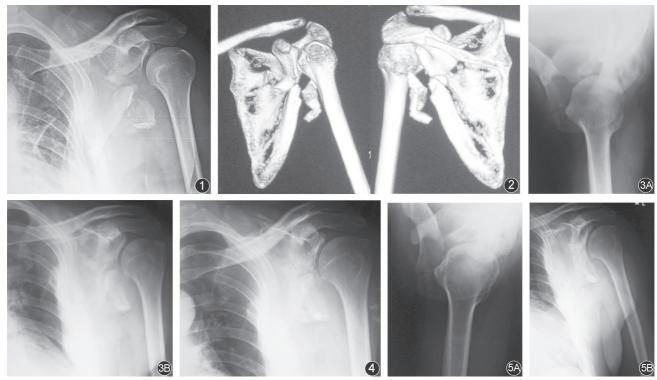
Anteroposterior radiograph of shoulder immediately after trauma. Figure 2. CT of shoulder immediately after trauma. Figure 3. Lateral (A) and anteroposterior (B) radiographs of shoulder 6 weeks after trauma. Figure 4. Anteroposterior radiograph of shoulder 3 months after trauma. Figure 5. Lateral (A) and anteroposterior (B) radiographs of shoulder 18 months after trauma.
